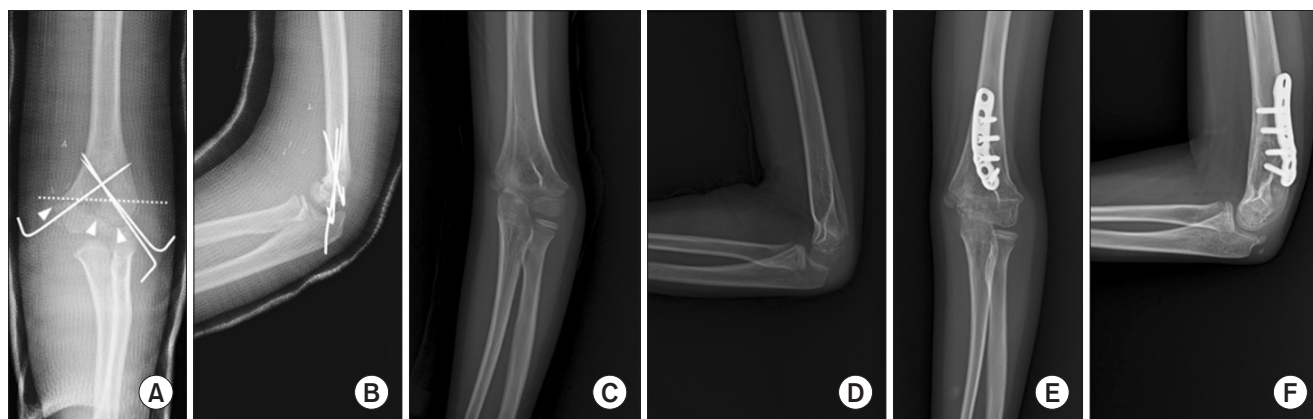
(A, B) A supracondylar humerus fracture of zone 3 (white arrowheads) in an 8-year-old girl was stabilized with two percutaneous 0.062-inch Kirschner (K)-wires laterally and one K-wire medially. (C, D) At 18 months postoperatively, on physical examination of the patient, a mild decrease in grip strength and weakness in hand intrinsic muscle were observed. On radiographs of the elbow, varus deformity of 22° and avascular necrosis of the trochlea were observed compared with contralateral radiographs. (E, F) Elbow deformity was corrected with a translation step-cut osteotomy using a locking plate.
